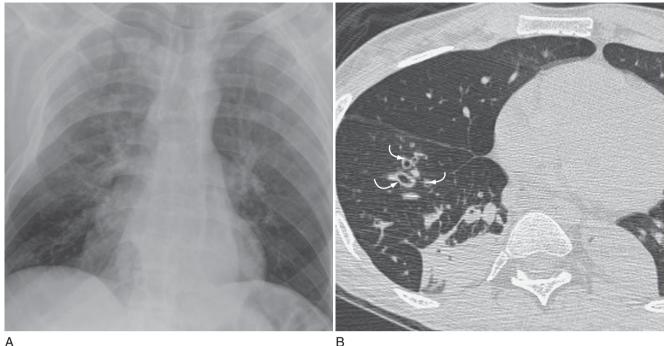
Aspiration: 17-year-old with a history of cerebral palsy and aspiration. A chest radiograph (A) demonstrated some subtle ill-defined opacities in the perihilar regions with bilateral lower lobe atelectasis. A CT scan (B) performed at the same time demonstrated bronchiectasis in the right lung base (curved white arrows), presumed secondary to recurrent aspiration. A further CT scan (C) performed 8 months later demonstrated a cavitary pneumonia in the same location, consistent with aspiration pneumonia.
